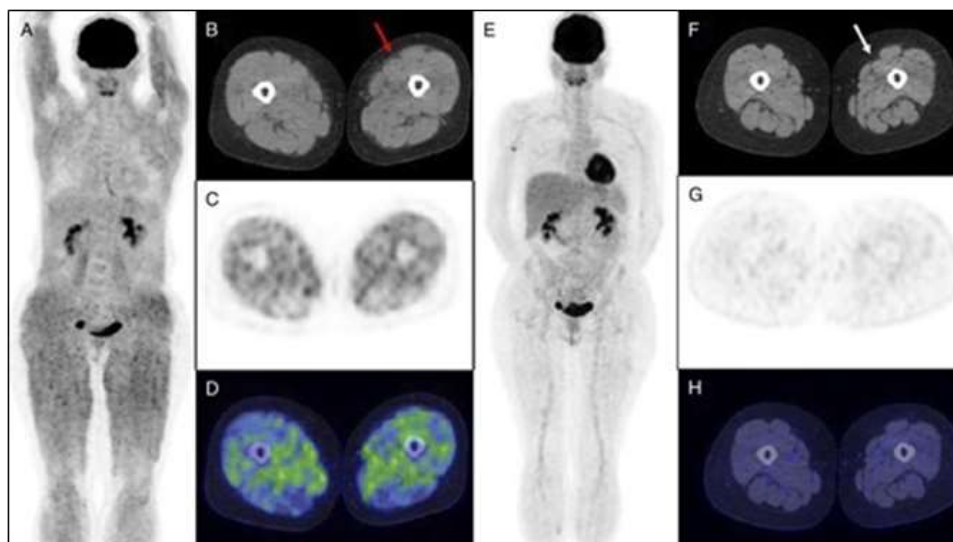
Demonstrating isolated muscular sarcoidosis, revealed by hypercalcemia and 18F-FDG PET/CT [7].
